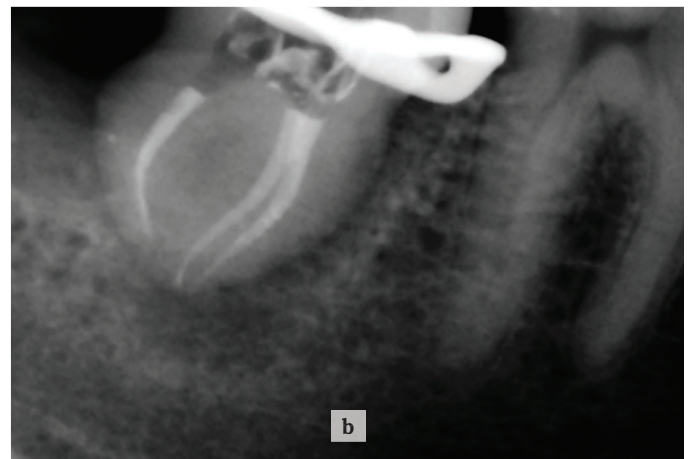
a, b. X-ray control of root canals obturation by the continuous wave method (in parallel and angulated projections).
